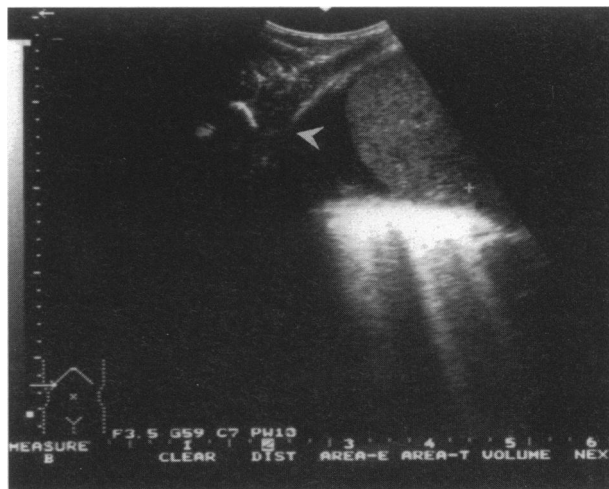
Abdominal ultrasonogram revealing a defect (arrow) in the right hemidiaphragm.
